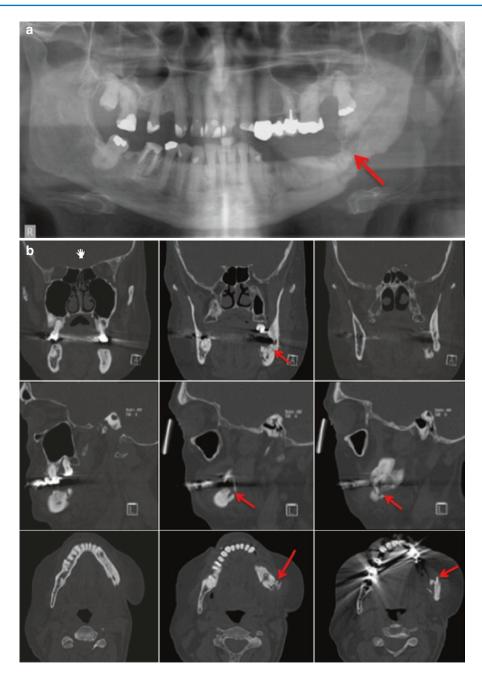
(a) Panoramic radiograph: Patient: 66 years old, male, secondary osteoporosis due to castration, alendronate. Red arrow indicates the almost invisible fracture. AAMOS staging: stage 3. (b) Computed tomography (Siemens, Sensation 64) of the same patient: 66 years old, male, secondary osteoporosis due to castration, alendronate. Red arrow points in the direction of the fracture due to the bisphosphonate necrosis. AAMOS staging: stage 3. (c) Planar scintigraphy (Siemens, Symbia) Blood pool phase. Of the same patient: 66 years old, male, secondary osteoporosis due to castration, alendronoste of the same patient: 66 years old, male, secondary osteoporosis due to castration, alendronoste operation of the same patient: 66 years old, male, secondary osteoporosis due to castration, alendronate. AAMOS
